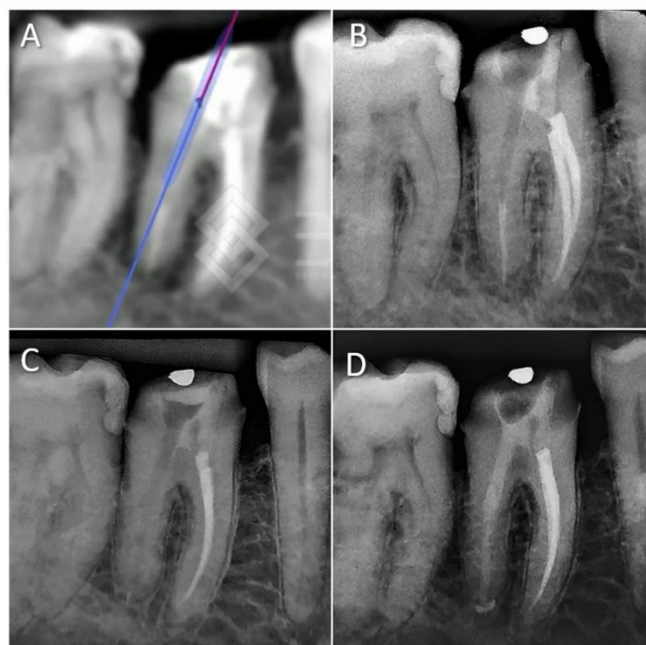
(A) Digital planning with details of the virtual positioning of the drill. (B) Trans-surgical radiography showing the wear caused by the implant drill. Note that there was no deviation from planning, allowing conservative access to the filling-material at the end of wear procedure. (C) Complete filling material removal. (D) Filling the entire distal root canal length with calcium hydroxide paste.
